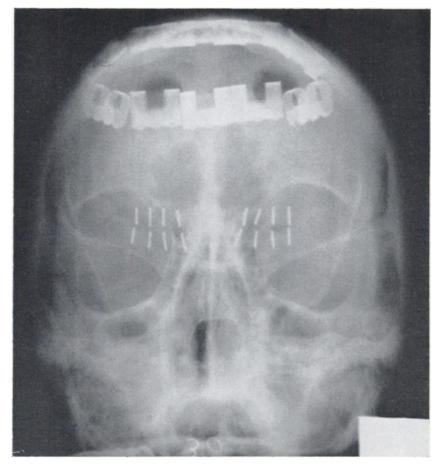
Antero-posterior X-ray view of yttrium seeds irradiating a plane 1.8 cm. wide by 2 cm. long.
